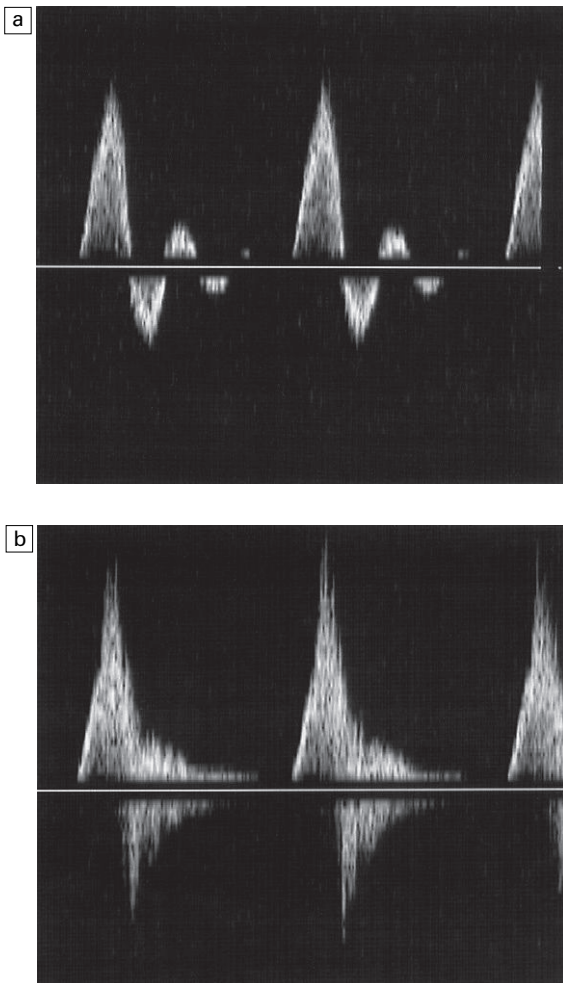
Femoral artery Doppler waveforms.
